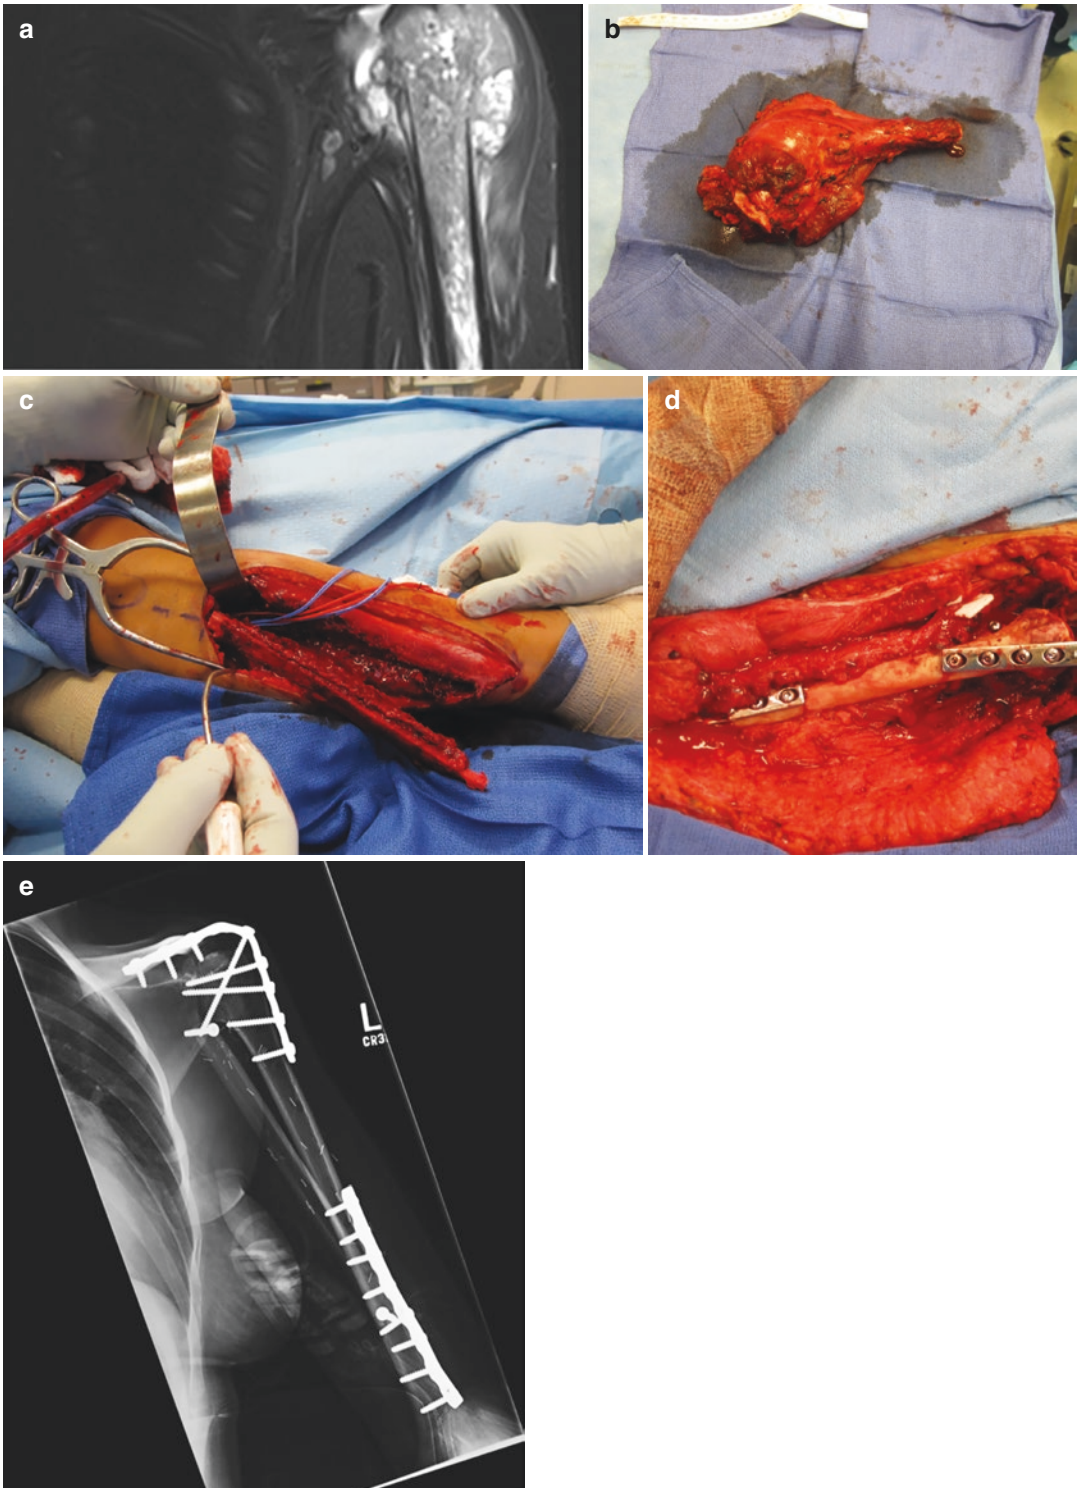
(a) X-ray appearance of osteosarcoma of the shoulder visualized as a large mass with periosteal elevation and local bone destruction. (b–e) Surgical resection of glenoid of humerus for osteosarcoma, with fibula harvest and anastomosis for reconstruction
